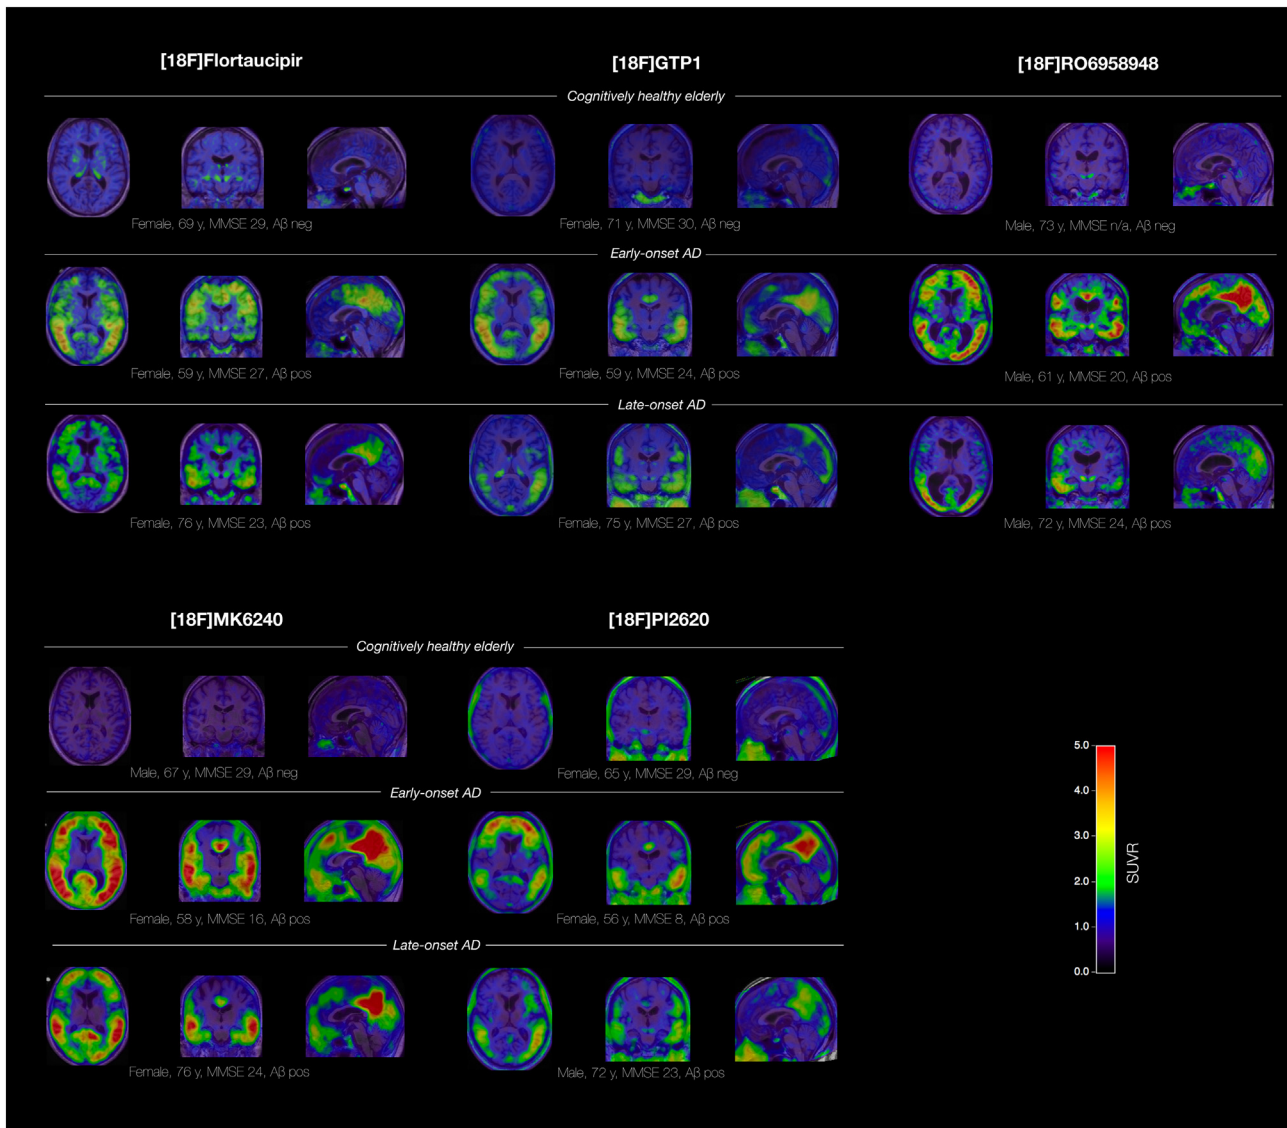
Representative PET scans using different current ligands presumably specific for tau in cognitively healthy elderly individuals (upper rows), patients with early-onset (EOAD, middle rows) and late-onset Alzheimer's disease (LOAD, lower rows). All images were processed in a unified manner including co-registration of PET to its corresponding T1-weighted magnetic resonance imaging (MRI) scan, spatial normalization to Montreal Neurological Institute (MNI) template space and creation of standardized uptake value ratios (SUVR) using an inferior cerebellum reference region (see (Baker et al., 2017b) for methods). Note that this is not a head-to-head comparison but merely a display of sample scans from different representative cases, obtained at various sites using scanners with different spatial resolution, and non-harmonized image reconstruction. FTP images (80–100 min SUVR) were derived from the Berkeley Aging Cohort Study (BACS; University of California, Berkeley/San Francisco, Drs. William Jagust and Gil Rabinovici), [18F]GTP1 (60–90 min SUVR) images were kindly provided by Genentech (Drs. Robby Weimer and Sandra Sanabria Bohorquez), RO6958948 images (60–90 min SUVR) by Roche (Drs. Gregory Klein and Edilio Borroni) and Drs. Dean Wong and Hiroto Kuwabara from Johns Hopkins University, Baltimore, Maryland, MK6240 images (90–110 min SUVR) by Drs. Pedro Rosa-Neto and Tharick Ali Pascoal at McGill University, Montreal, Canada, and PI2620 scans (60–90 min SUVR) by Drs. André Müller and Santaigo Bullich at Life Molecular Imaging GmbH (former Piramal Imaging). Aβ pos/neg: Amyloid status positive/negative based on Aβ PET scans; MMSE = Mini Mental State Examination.
